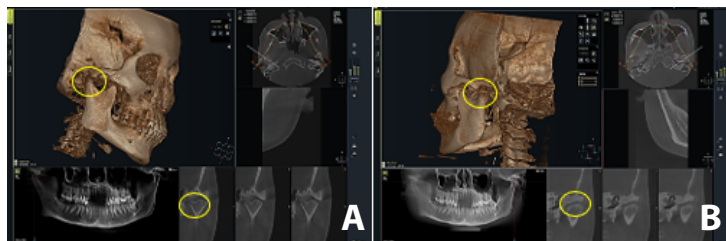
Radiographic examination, A. Of the TMJ in the closed and open positions, B. Panoramic
